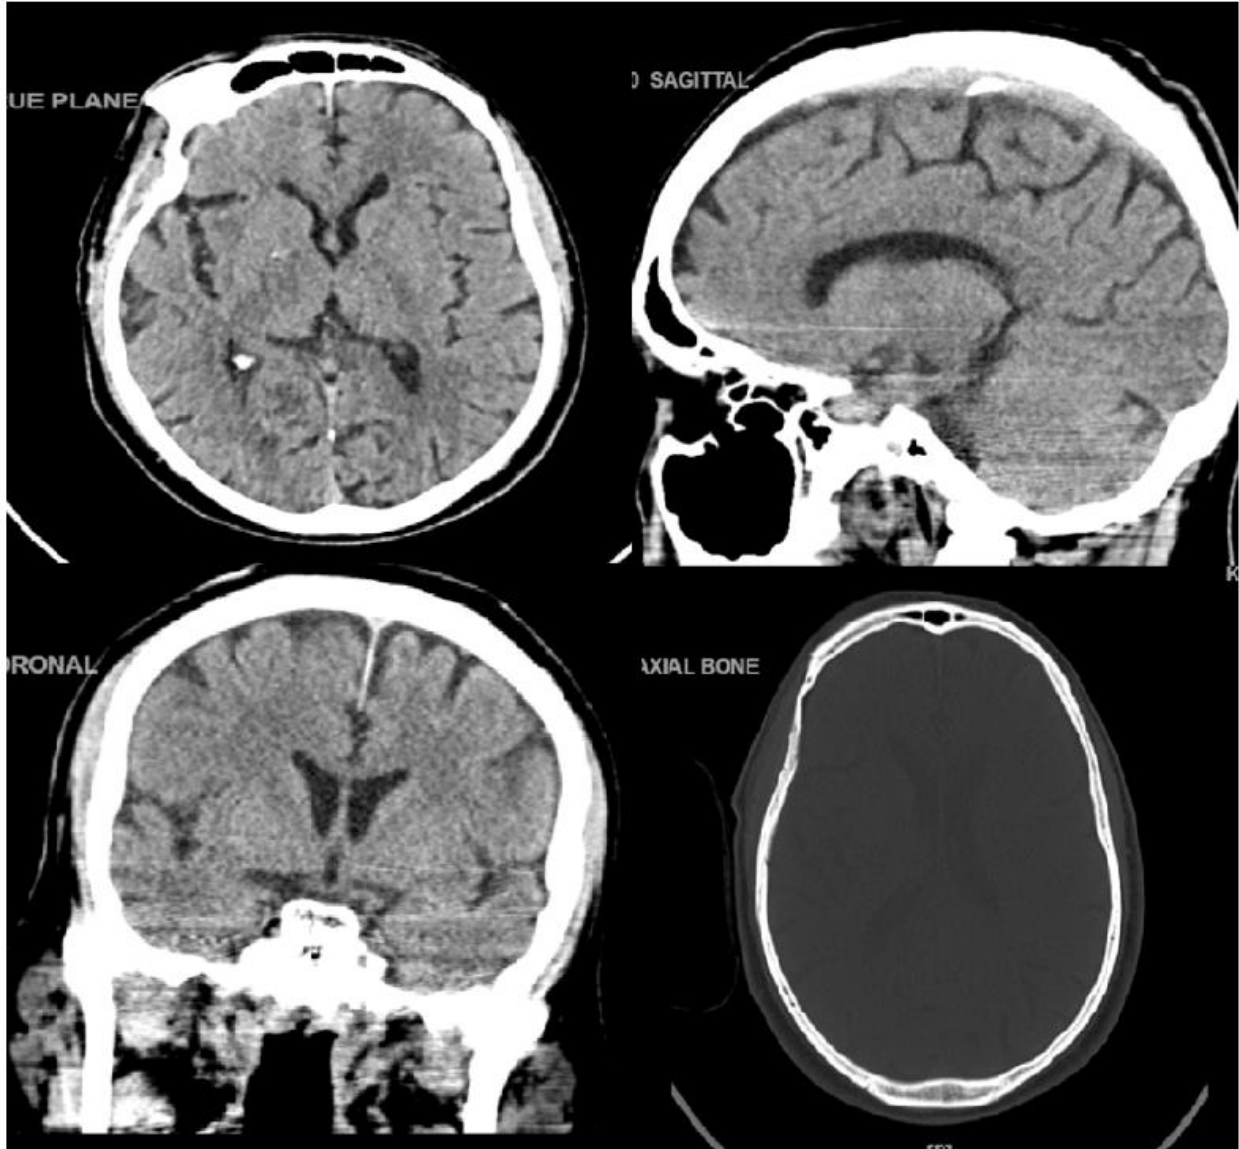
Computed Tomography report
